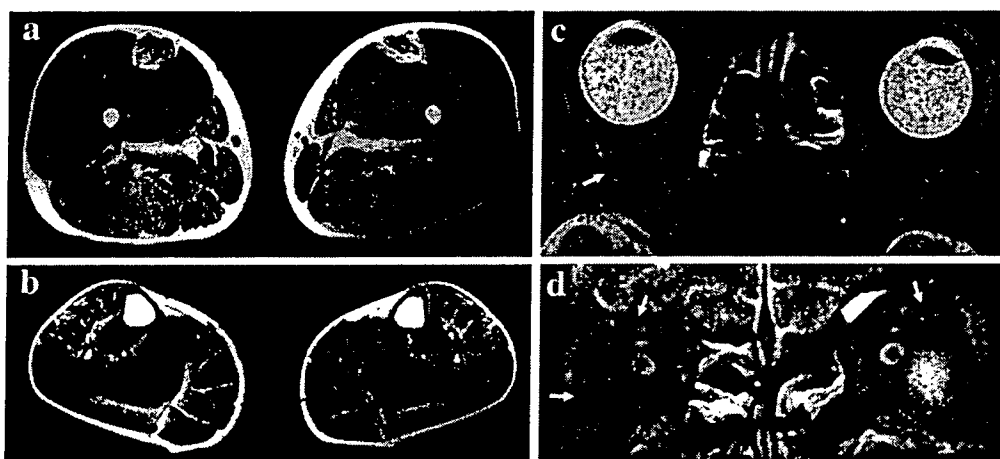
T2-weighted skeletal muscle MRI of the lower limbs demonstrates areas of high signal intensity and mild atrophy in the bilateral gracilis, biceps femoris, and tibialis anterior muscles. (a) Thigh medial level, (b) leg medial level. T2-weighted, fat-suppressed orbital MRI shows atrophy of the bilateral superior and lateral rectus muscles (arrows). (c) Horizontal section, (d) coronal section.
